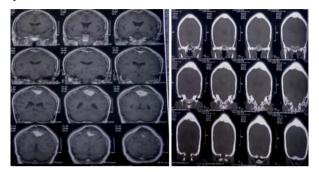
Preoperative MRI and CT bone window of the brain showing parasagittal meningioma
